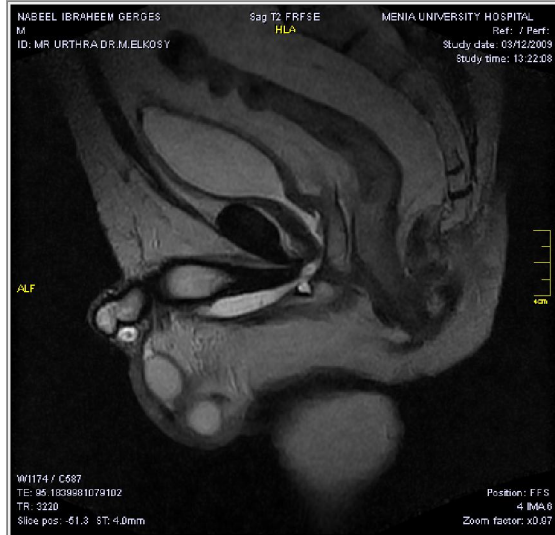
Sagittal T2-weighted MR image showing well delineated urethral diverticulum
